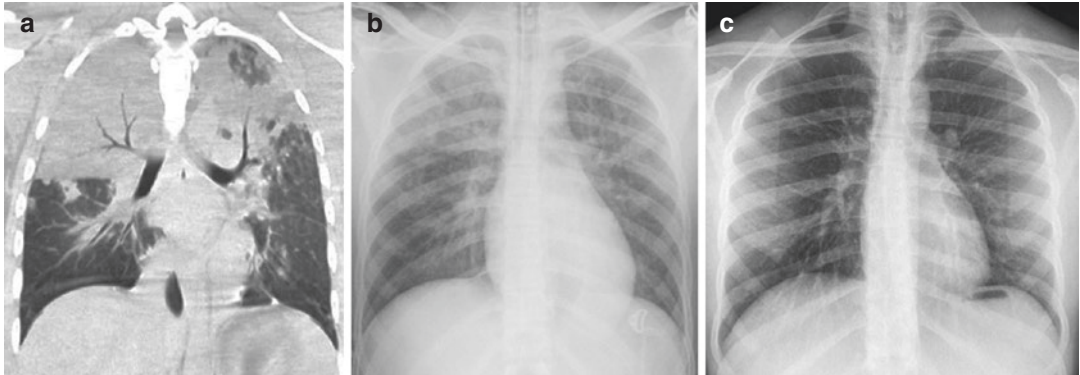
Bilateral parenchymal contusion. Coronal CT-reconstruction immediately after trauma (a) shows large parenchymal consolidations. Chest X-ray (CXR)
